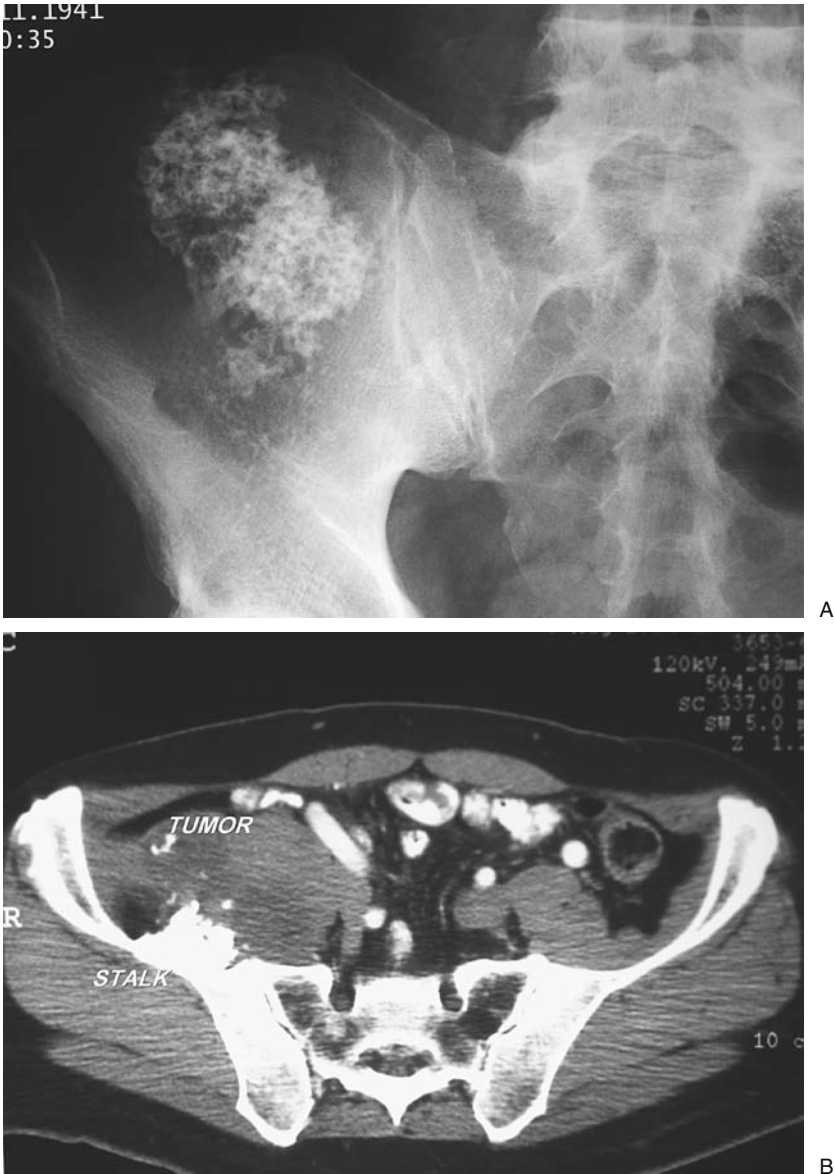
Chondrosarcoma. (A) Plain AP radiograph demonstrates a large central calcification of the right ilium, approaching the sacroiliac joint. This patient has a fairly well-defined lytic lesion showing calcification, which is typical of chondrosarcoma. (B) Computed tomography (CT) scan demonstrates secondary chondrosarcoma and a large soft tissue component. Chondrosarcomas are the most common malignancies of the pelvic bones. Large soft tissue components are common. Note the stalk indicating a preexisting exostosis.
